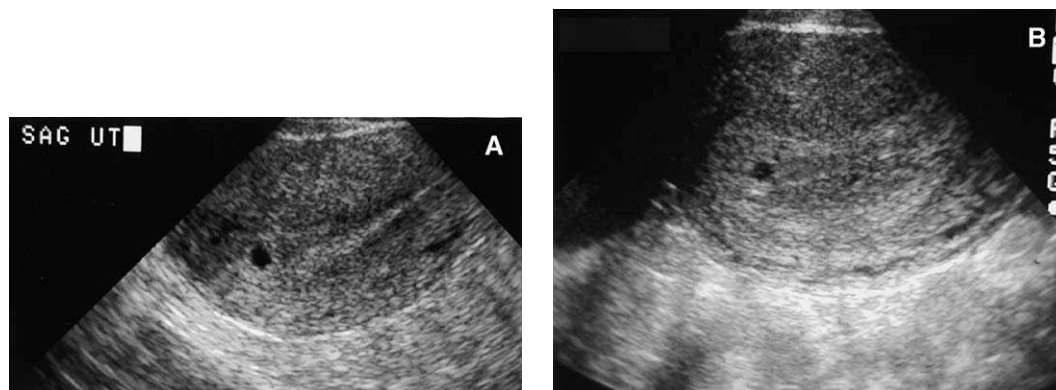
(A) Sagittal and (B) transverse sonographic views of the gravid uterus demonstrate the “intradecidual sac sign”: echogenic material surrounding a small cyst-like fluid collection located eccentrically within the endometrium.
